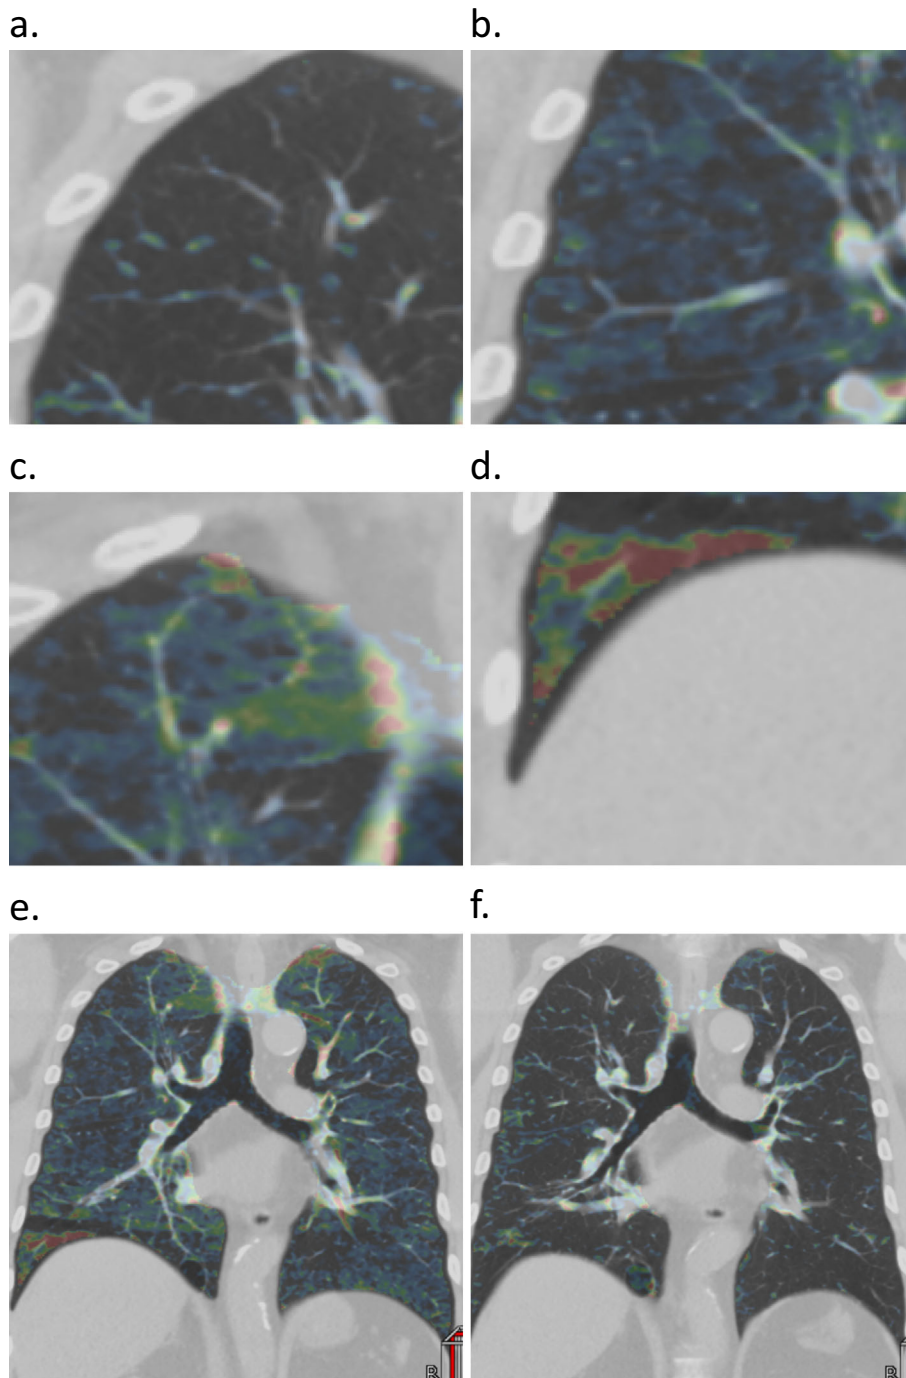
The assessment of the air trapping scores in each pulmonary segment with wash-out phase Xe-CT. Depending on the maximum xenon intensity in each segment, the scores were defined as none (a), mild (b), moderate (c), and severe (d). Representative Xe-CT images at baseline (e) and after the third BT procedure (f).
